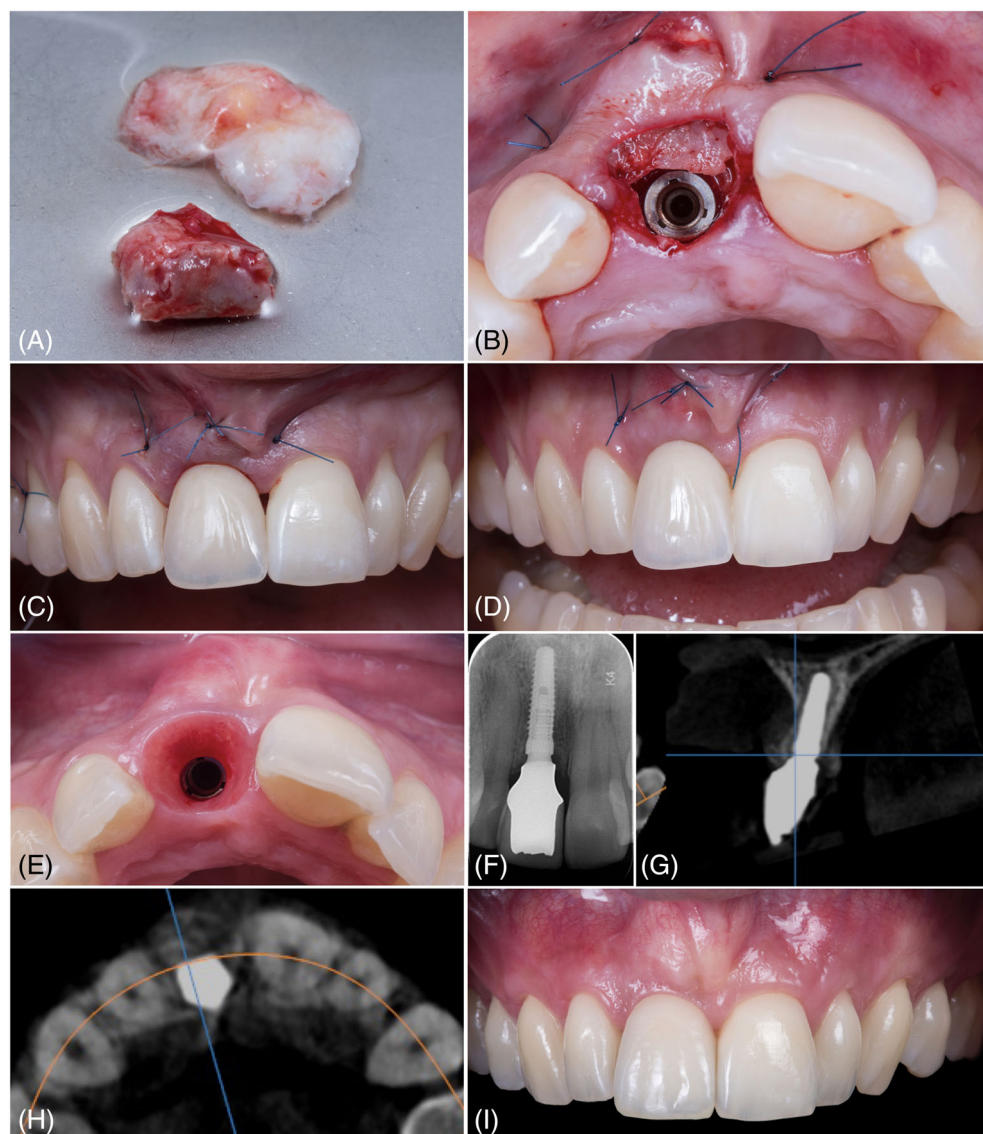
(A) Connective tissue graft and bone block harvested from the right maxillary tuberosity. (B) After placing the triple graft to the level of the implant platform. Note the connective tissue graft was in contact with the internal part of the gingival flap. (C) A screw-retained resin provisional crown, relined over a polyetheretherketone (PEEK) anti-rotation abutment, was placed out of occlusion. (D) Correct accommodation and maintenance of the soft tissue s14 days post-surgery. (E) Occlusal view tooth extraction and implant placement at 4 months. (F) Three-year follow-up: facial view. (G,H) CBCT examination showing stable buccal bone plate at 3 years. (I) Three-year clinical control showing healthy and stabilized peri-implant soft tissues
